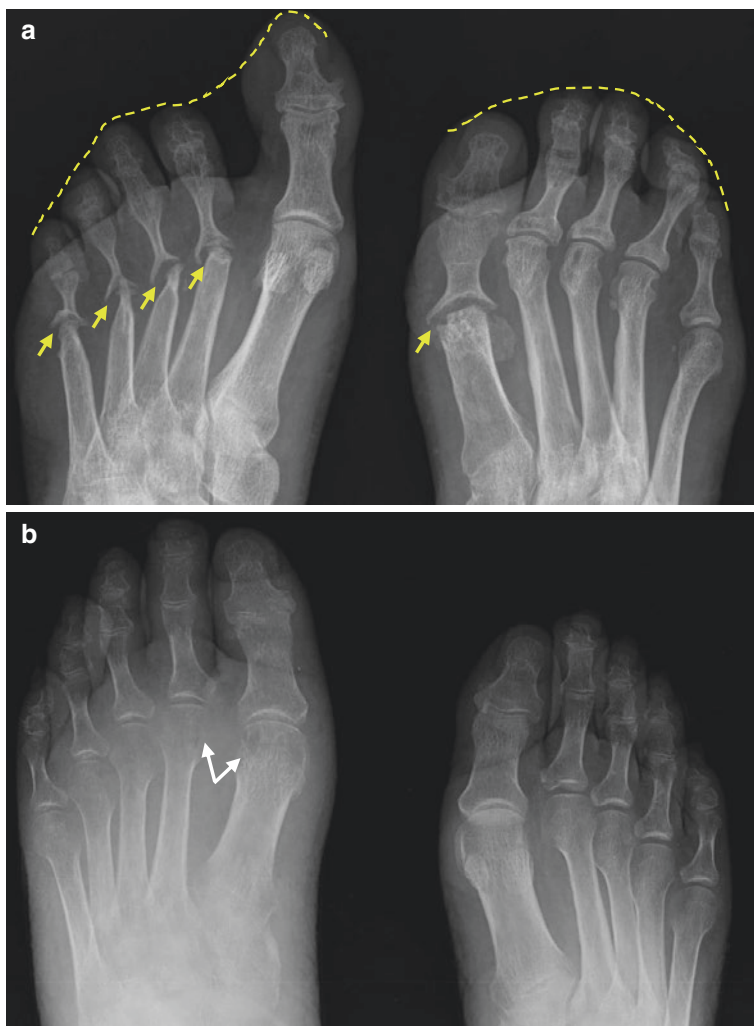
Radiographic findings – feet
